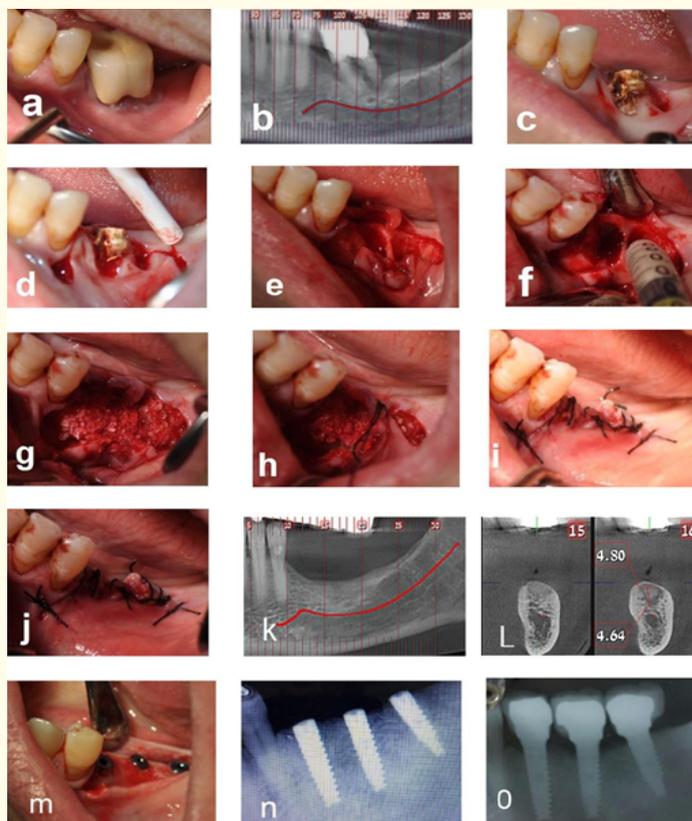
Clinical and radiographic views, advanced periodontal lesion that affected the first left mandibular molar.
